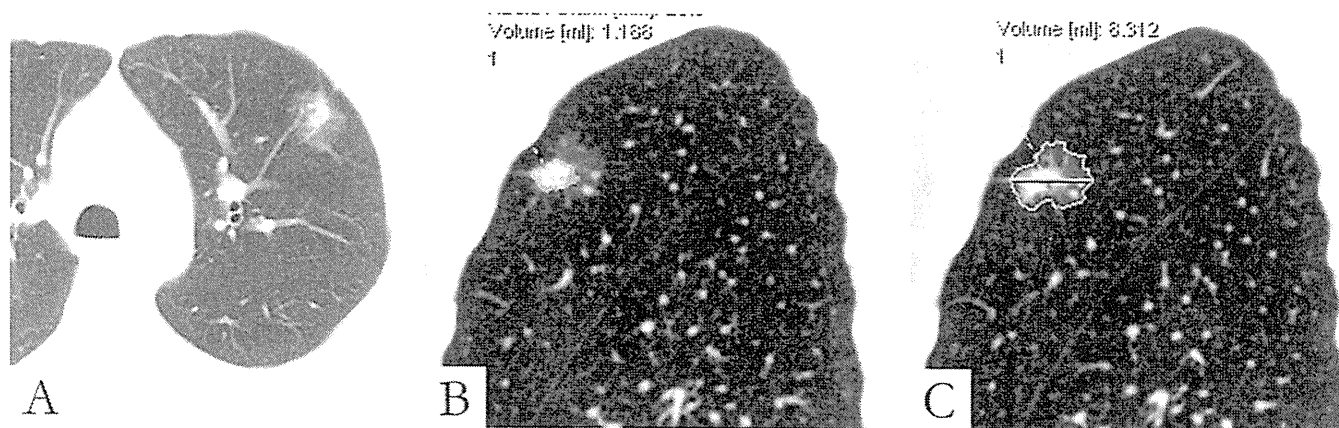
Invasive adenocarcinoma. *A*, Axial CT image shows a part-solid nodule in the left upper lobe. *B*, Corresponding sagittal CT images show automated estimation of the volume of (*B*) the solid component (1.188 cm³) and (*C*) the entire lesion (8.312 cm³). In this case, if tumor size were measured only by the invasive component, the size T factor would change from T2a (3.2 cm) to T1a (1.8 cm). Recording of total and invasive sizes are suggested until it is known whether invasive size predicts prognosis better than total size. CT, computed tomography.
